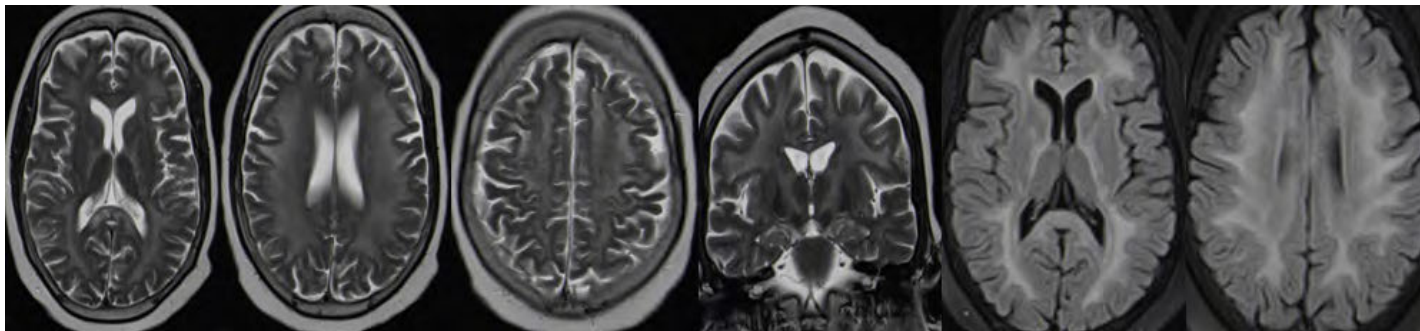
Patient 2: T2 and flair axial and coronal MRI brain scans
